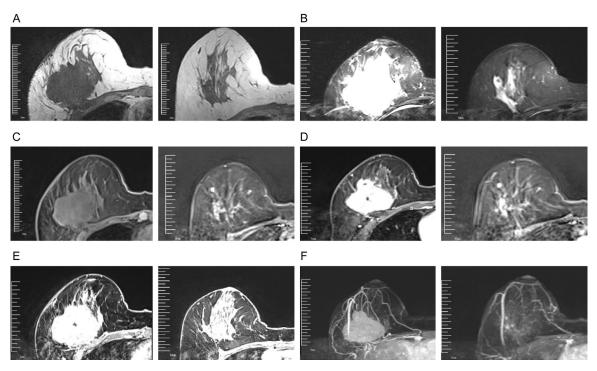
MRI was performed using the 3.0-T system. A. On axial non-fat-saturated T1-weighted images, mass shows round, smooth, homogeneous, low signal intensity. B. On axial fat-saturated T2-weighted images, mass shows high signal intensity. C. Axial fat-saturated pre-contrast-enhanced. D. Early (2 minutes) contrastenhanced. E. Delayed (6 minutes) contrast-enhanced axial T1-weighted images after bolus administration of gadolinium-based contrast agent show heterogeneous enhancement. A cloudy-like area without potentiation can be seen in the enhancement area, and images reveal fast-in and fast-out pattern enhancement. F. On delayedcontrast-enhanced axial T1-weighted image reconstruction, shows a well-defined irregular heterogeneous enhancing mass in right breast parenchyma.
